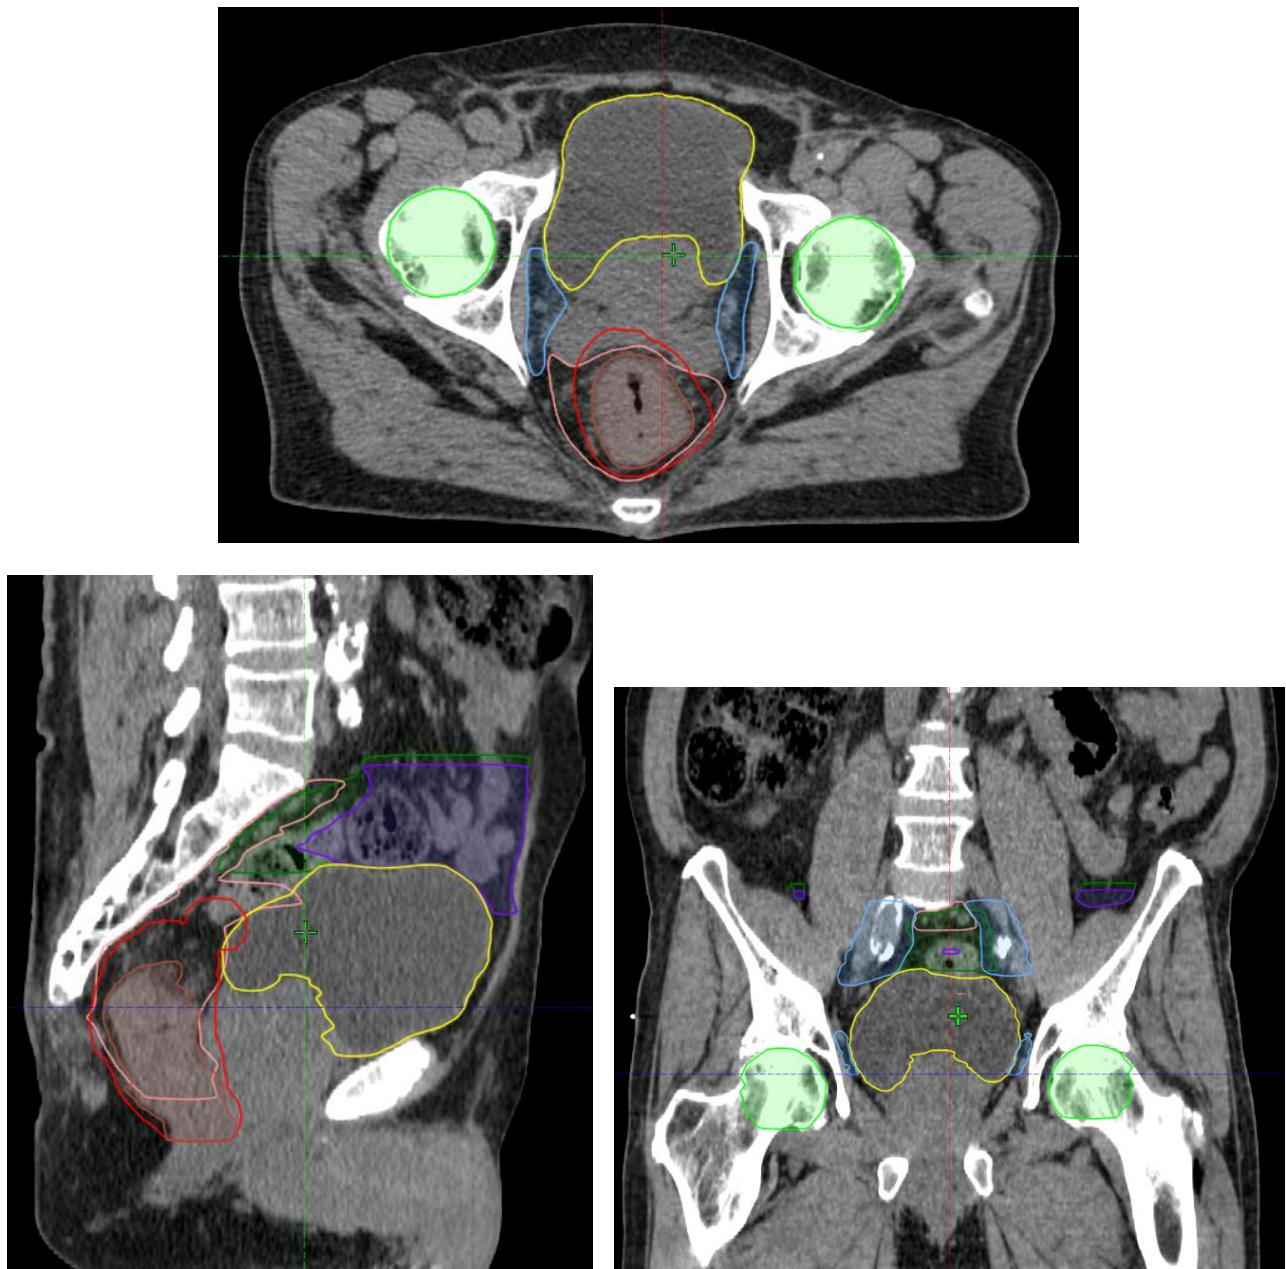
CT scans showing pelvic anatomy and target definition. Brown = surrogate, pink = CTV-E1, dark blue = CTV-E2, yellow = bladder, dark green = Bowel, purple = oBowel, light green = femoral heads.
